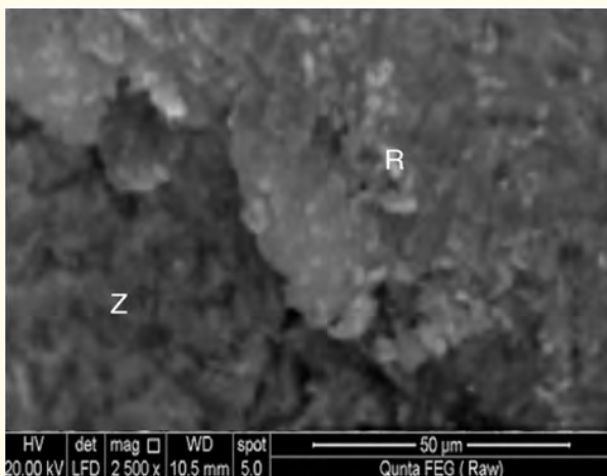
SEM of CT zirconia(Z) showing resin cement(R) covering the surface.
